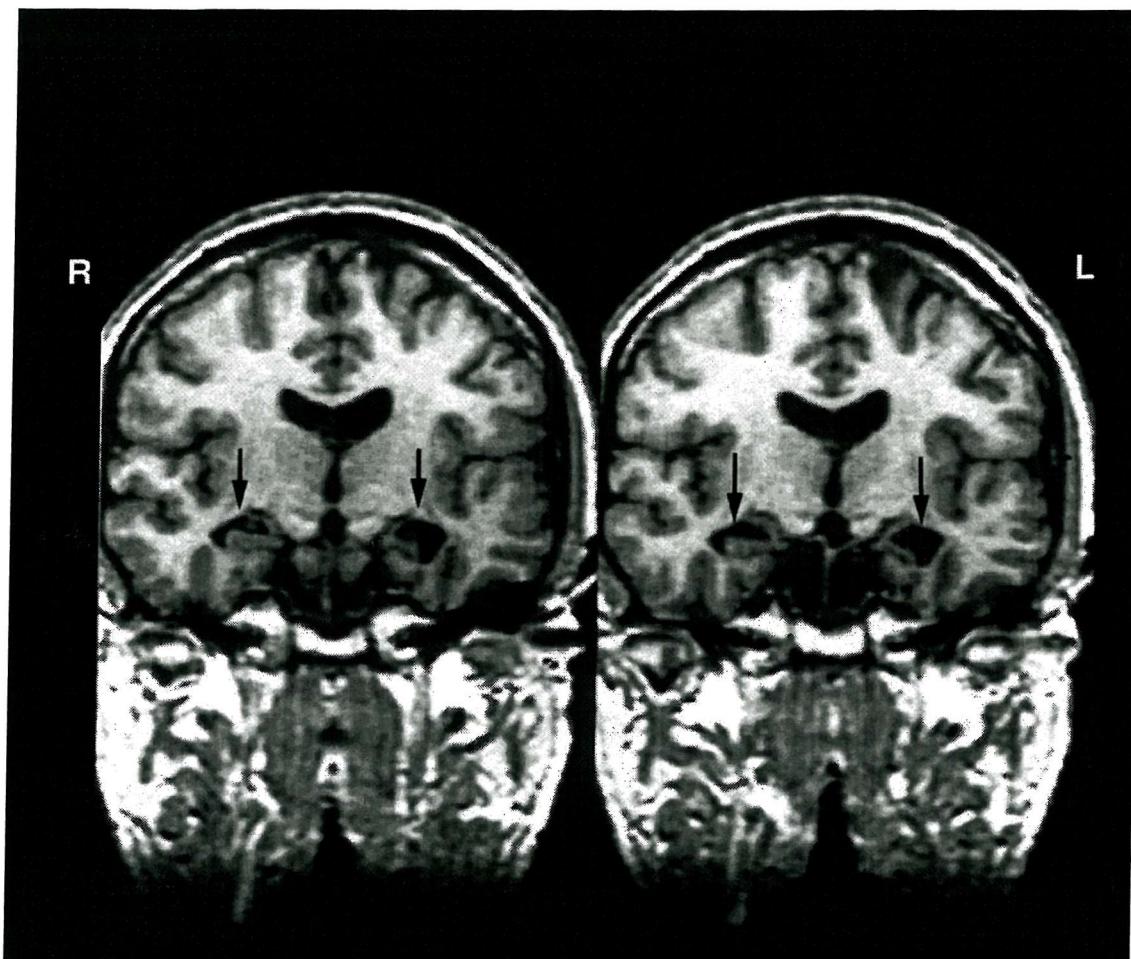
Coronal MRI scan of JC's brain showing left and right hippocampal atrophy (arrowed).
